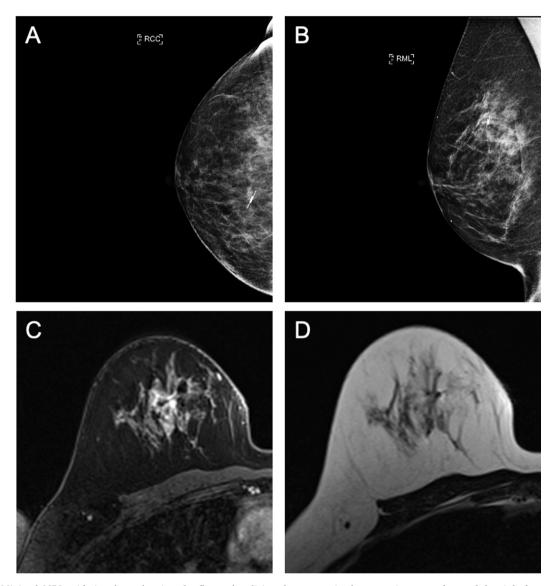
Minimal MRI void signals at the site of reflector localising the tumour in the upper inner quadrant of the right breast. (A) Right craniocaudal mammogram view. (B) Right mediolateral oblique mammogram view. (C) T1 non-subtracted MRI image post contrast. (D) T2 MRI image showing minimal MRI signal void.
